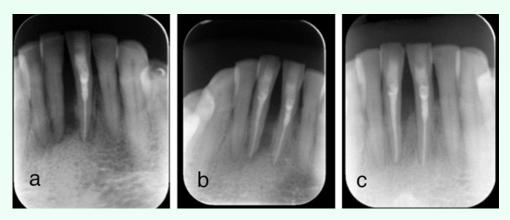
a) Initial radiograph of case presented in Fig.2 before endodontic treatment. b) Radiograph taken 3 months after endodontic treatment. Note the apical bone healing. c) Radiograph taken 8 months after surgery. Substantial amount of regeneration can be seen.
